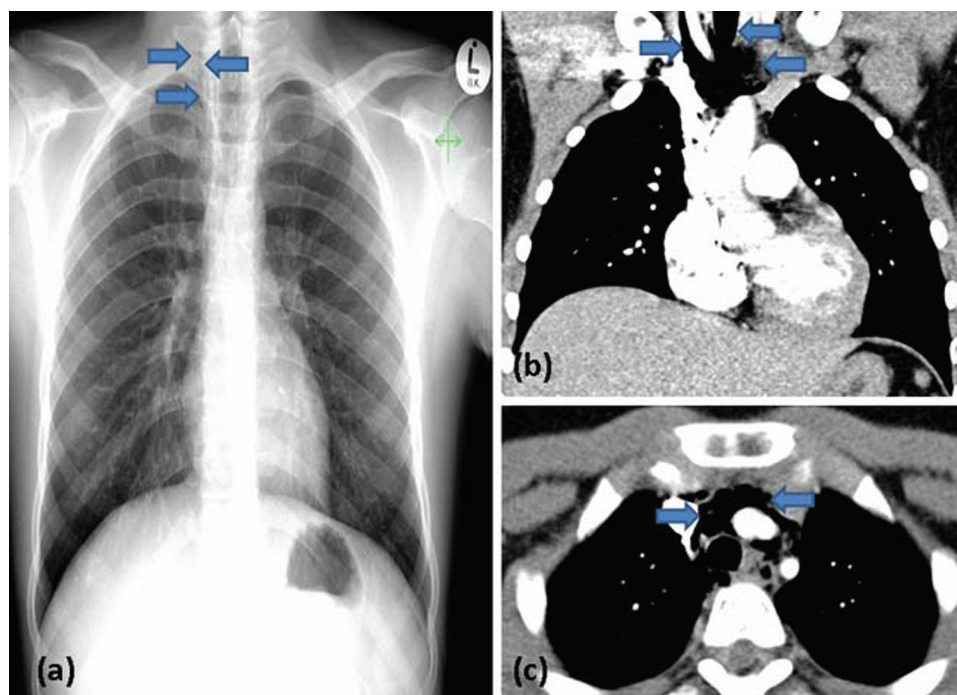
(A) Chest x-ray with mild signs of pneumomediastinum as shown by arrows. (B, C) Chest CT scan clearly demonstrating air within the superior mediastinum. No abnormalities were identified in the lung fields.
